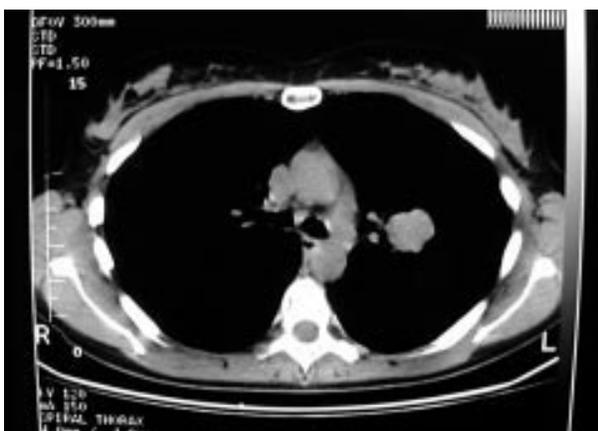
Computed tomography scan showing a well defined mass in the medial left chest abutting the left upper lobe bronchus.
